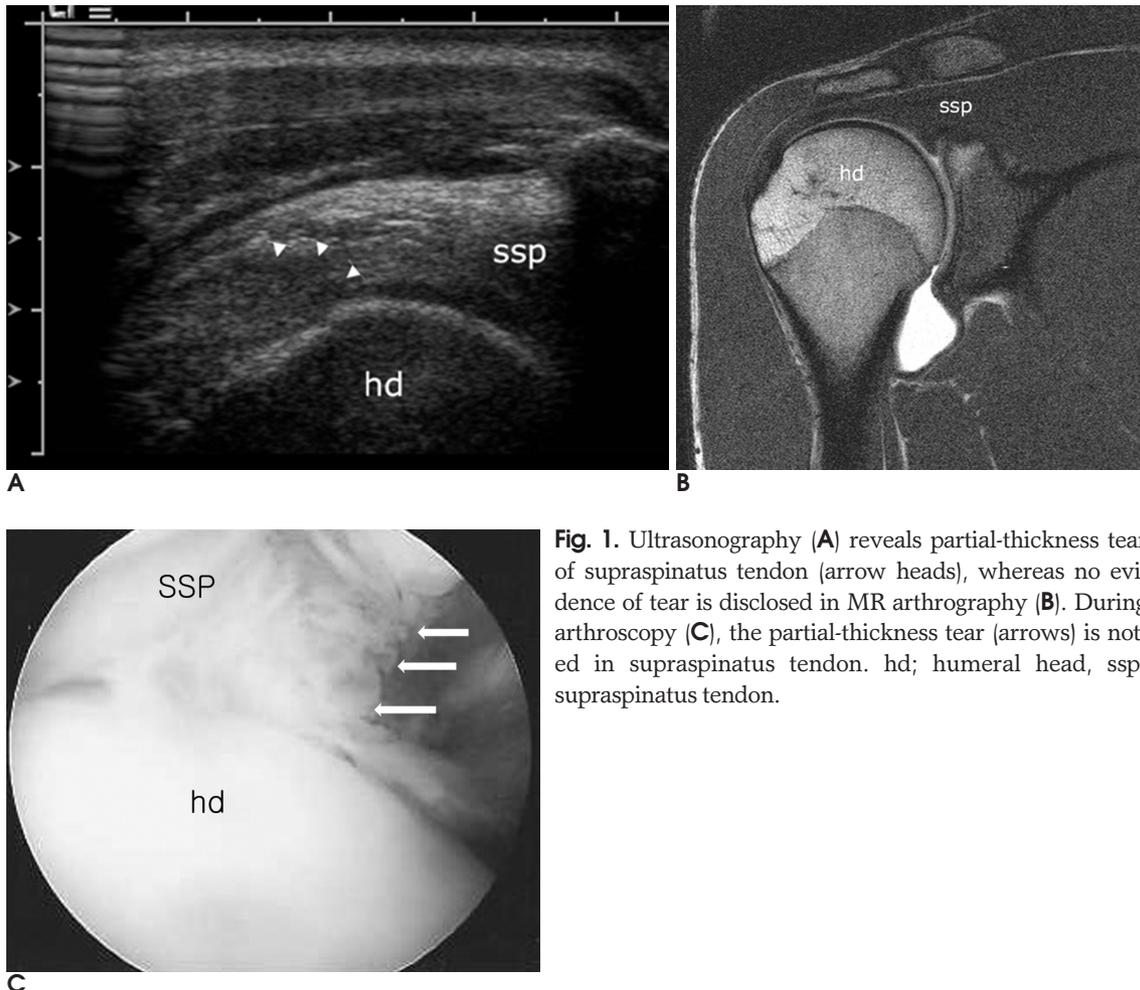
Ultrasonography (A) reveals partial-thickness tear of supraspinatus tendon (arrow heads), whereas no evidence of tear is disclosed in MR arthrography (B). During arthroscopy (C), the partial-thickness tear (arrows) is noted in supraspinatus tendon. hd; humeral head, ssp; supraspinatus tendon.
